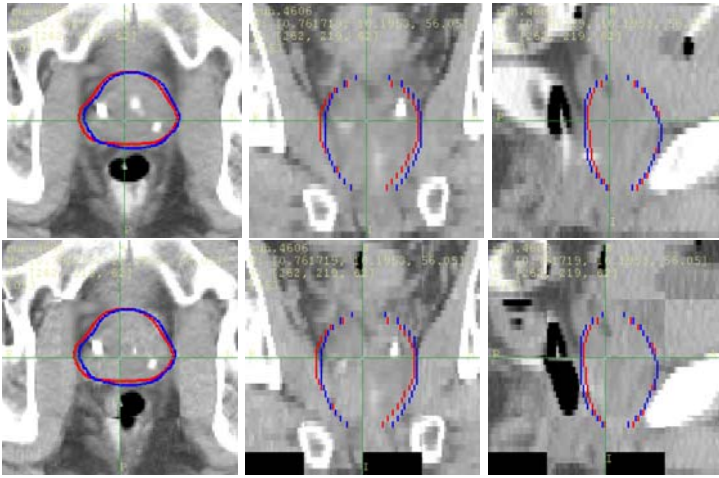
Axial (left), coronal (center), and sagittal (right) views of an example m-rep comparison; blue contour: m-rep fitted to Calypso marker locations during the treatment fraction; red contour: m-rep created with real treatment image; the green crosshairs show the Calypso origin, which also serves as the isocenter of the treatment plan; the CT image shown are the estimated image (top row) and the 4×4 checkerboard image comparing the estimated image to the real treatment image (bottom row).
